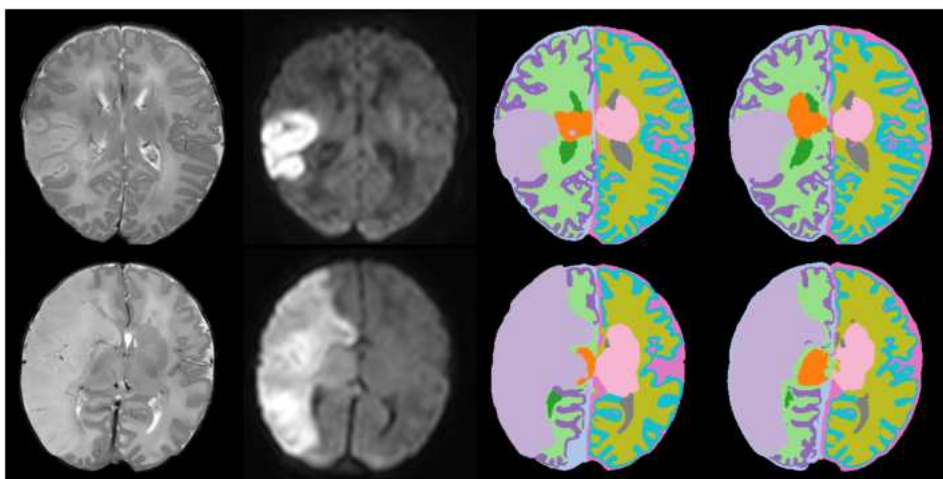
Example of brain tissue and ischemic lesion segmentations on the baseline scans for two patients (top and bottom row). From left to right: T2-weighted scan, DWI scan, reference segmentation and automatic segmentation. The top row shows an example on which the network successfully segmented the hemispheres and the brain tissues. The bottom row shows a DWI scan on which the ischemic lesion is undersegmented and the basal ganglia are oversegmented by the automatic method.
